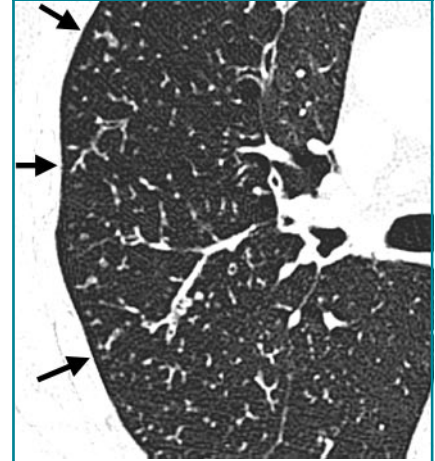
Transverse CT scan shows tree-in-bud pattern (arrows).
